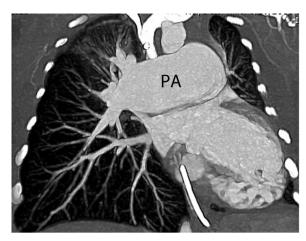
The enlargement of the pulmonary arteries causing compression of the bronchi in a neonate is visible on the chest CT scan. PA, pulmonary artery.
